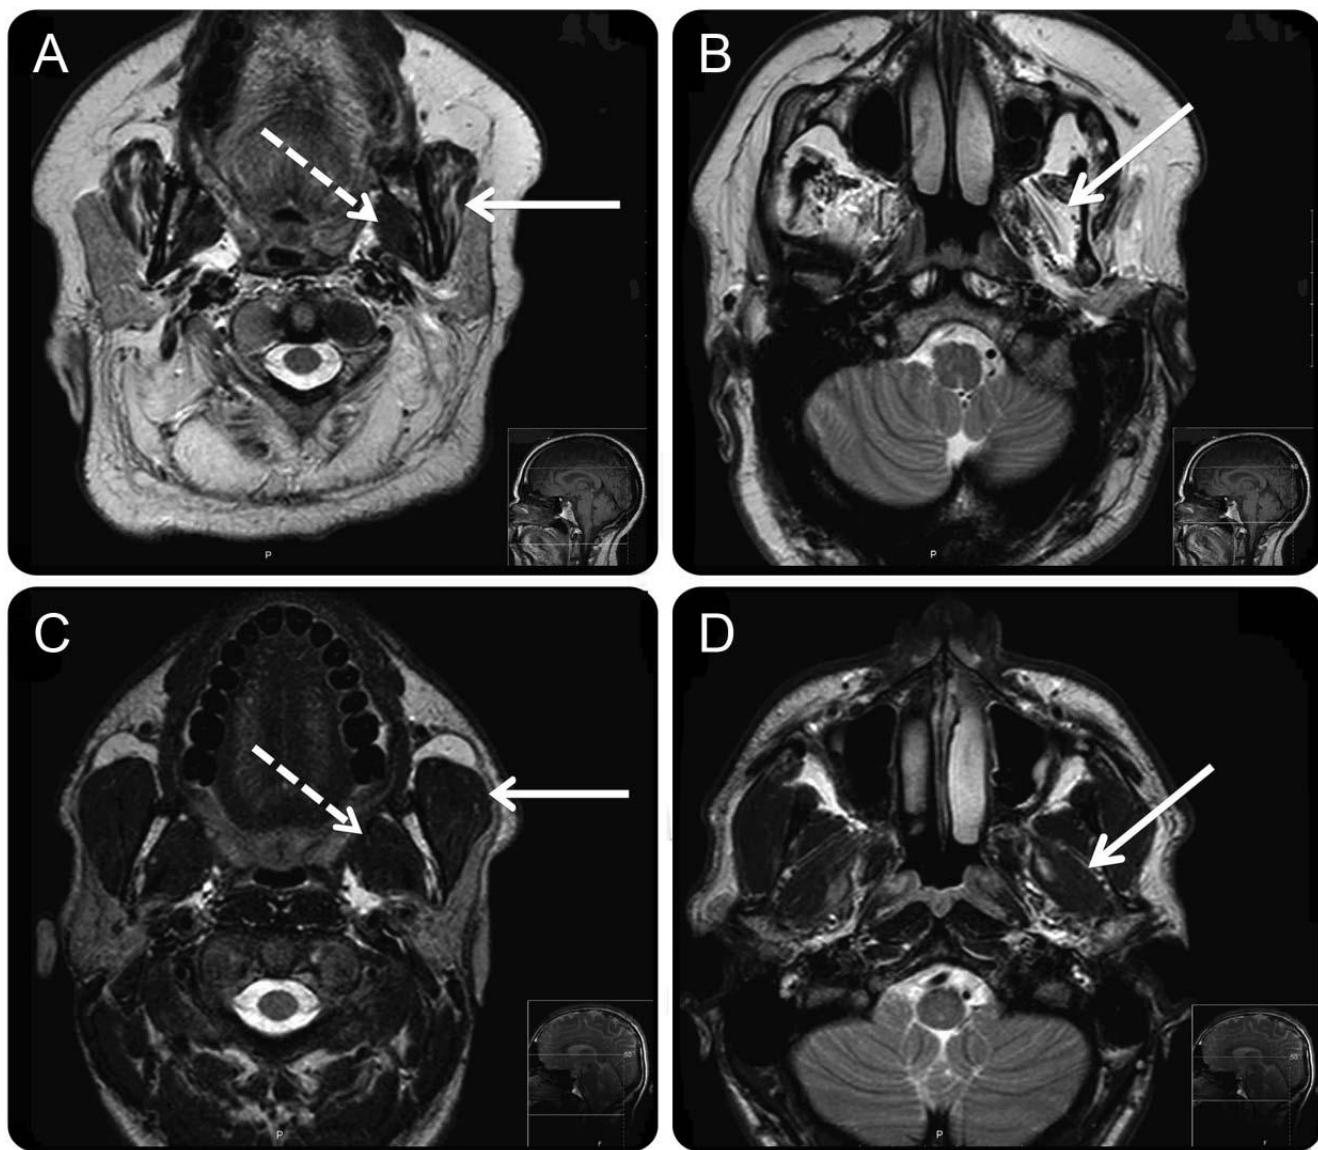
MRI of bulbar muscles in a patient with SMA and a healthy control.
